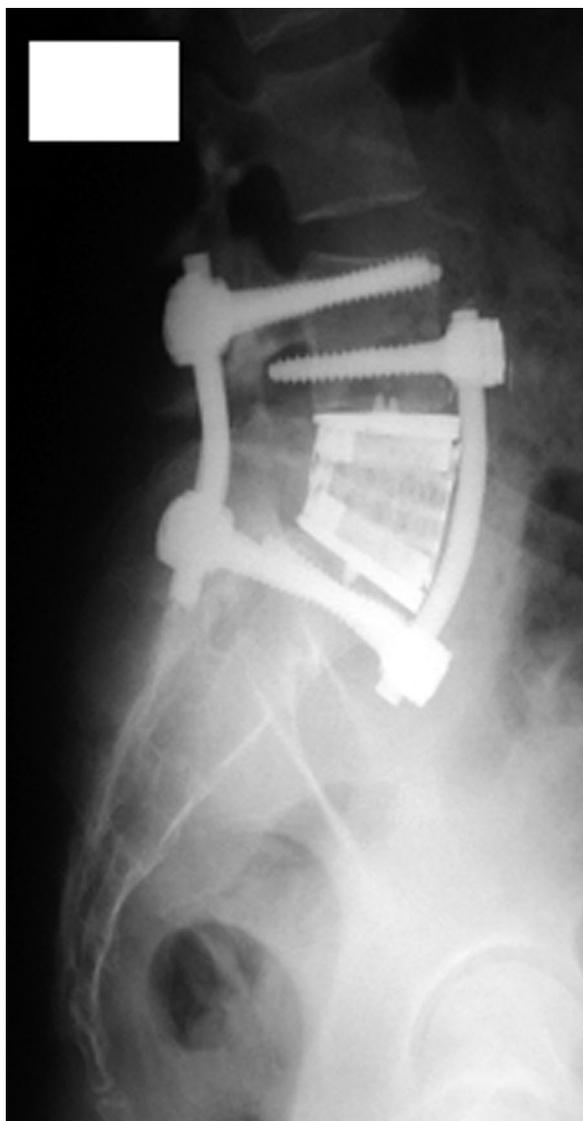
Post operative lateral radiograph shows pedicular screws and anterior body fixation in L4 and S1 with an interbody cage at L5.
